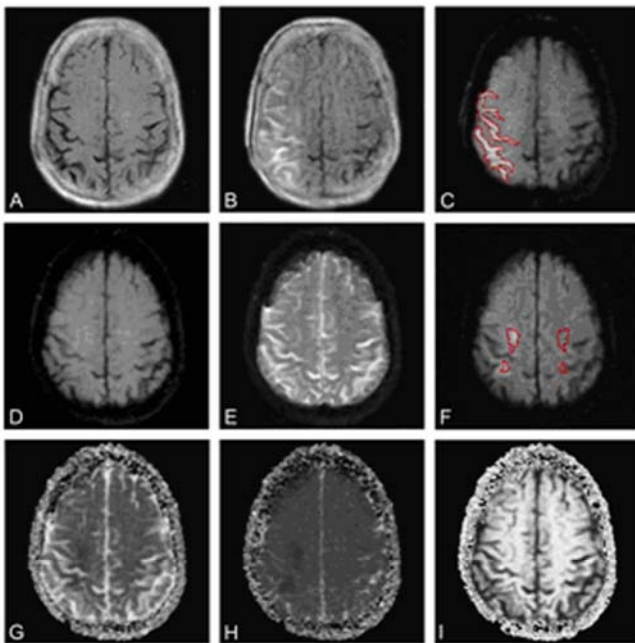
A) FLAIR_{pre}. B) FLAIR_{post}. C) FLAIR-DWI_{post} with ROI delineation of HARM. D) FLAIR-DWI_{pre} ($b = 0$). E) DWI_{pre}. F) DWI-ISO_{pre} with ROI delineation of ischemic lesion and the comparable contralateral control. G) ADC. H) CSF-suppressed ADC. I) Volume Fraction of Parenchyma (λ_{app-p}).
